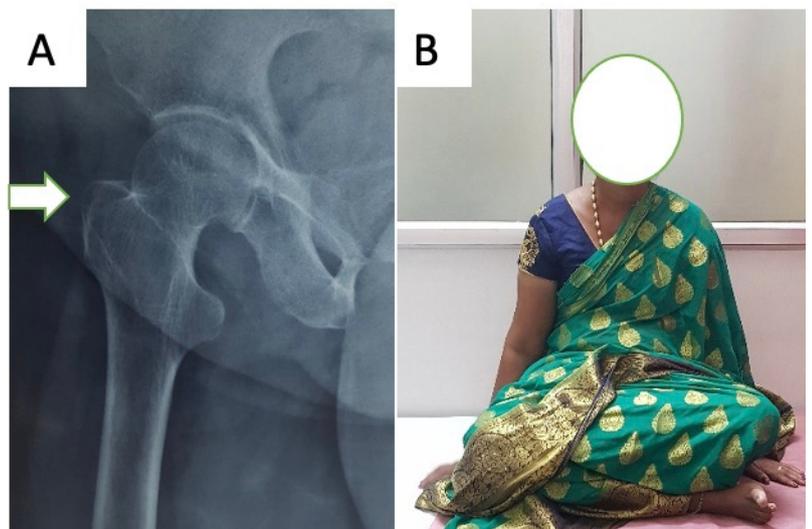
1 Year Post operative Follow up. A: Post operative radiograph showing complete resection of marginal osteophyte B: Clinical image showing patient sitting cross legged comfortably without any pain
